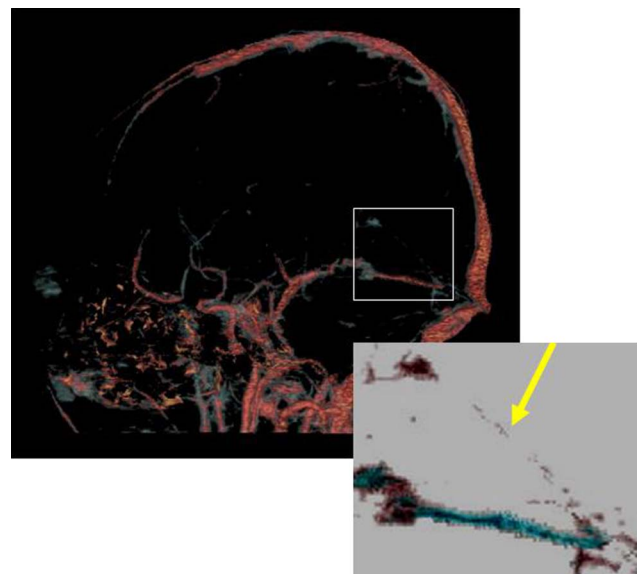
CT venogram 18 h post-treatment showing partial recanalisation of straight sinus (box indicates area of detail shown with inverted colours).
